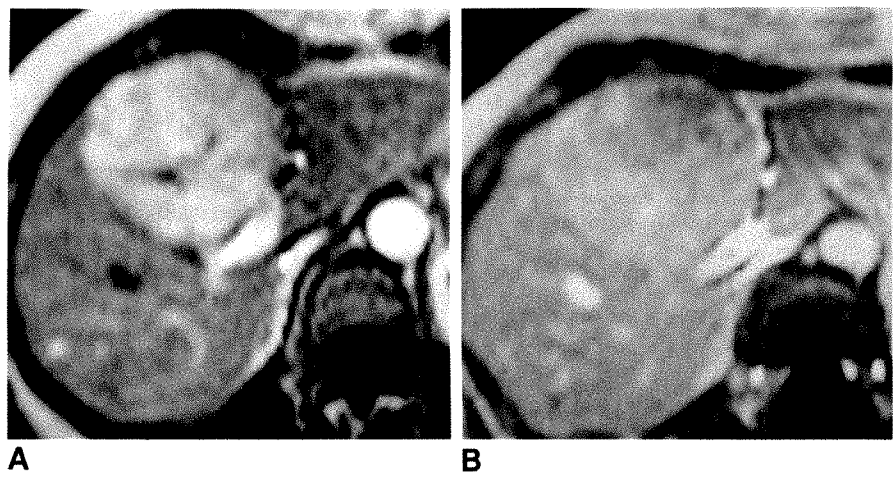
Dynamic gadopentetate dimeglumine-enhanced MR images (GRE 100/5, 80°) of focal nodular hyperplasia at 1.5 T. Note immediate (A, 30 sec) and strong enhancement of hyperperfused lesion, which subsequently becomes isointense on delayed scans (B, 4 min). Thus focal nodular hyperplasia shows rapid fill-in and rapid washout of contrast agent.
